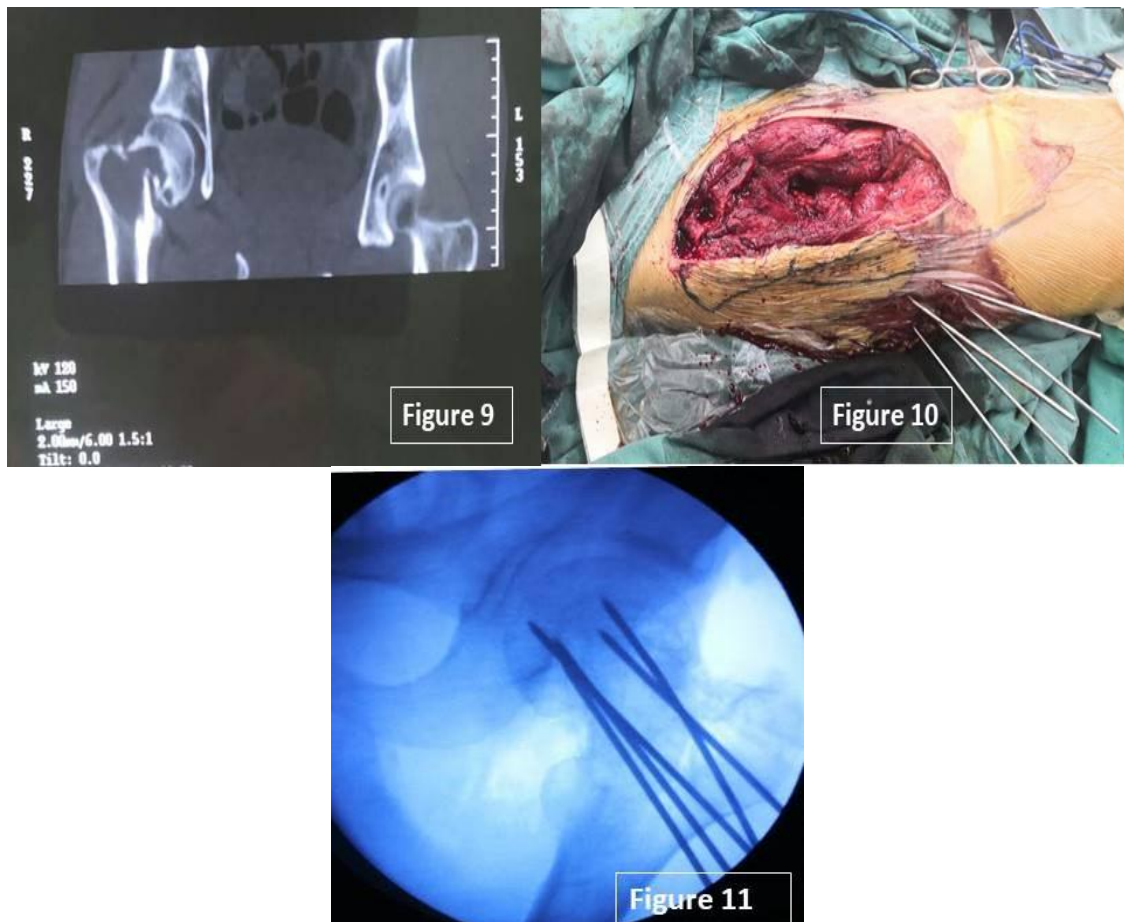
anatomical markings, denotes femoral nerve artery and vein, Figure 8 and 9: pre-operative X-ray and CT shows the fracture caused by bone defect, Figure 10 and 11: the iliac bone graft is harvested and fixed using guide k-wire.
